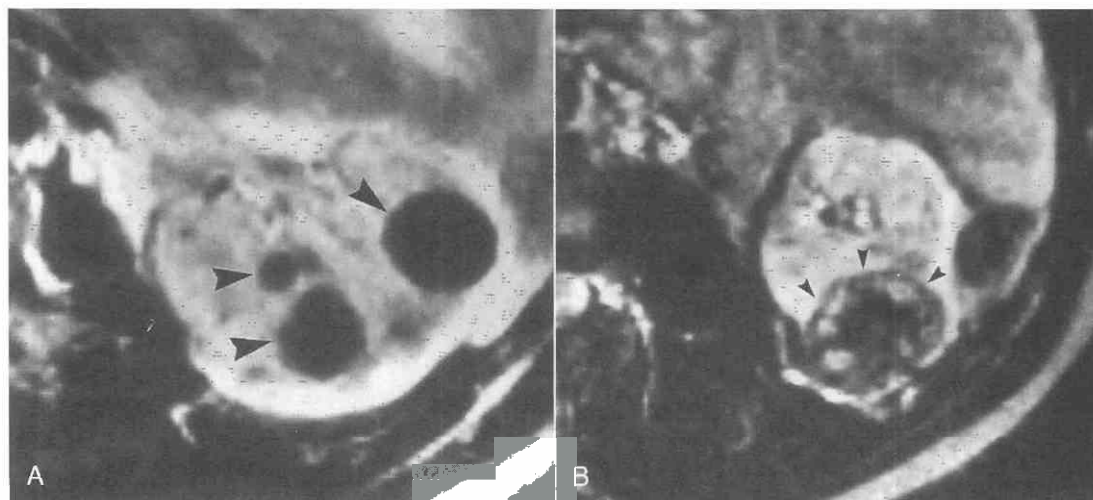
Acquired renal cystic disease and left renal cell carcinoma in a 59-year-old man with azotemia not treated with dialysis. *A*, T1-weighted (TR = 440 msec, TE = 17 msec) spin-echo MR image after gadolinium DTPA administration shows several well-defined cysts (arrowheads) of low signal intensity in the left kidney. *B*, T2-weighted (TR = 2100 msec, TE = 90 msec) image without gadolinium administration reveals a heterogeneous, 3.5-cm lower-pole carcinoma (arrowheads).
